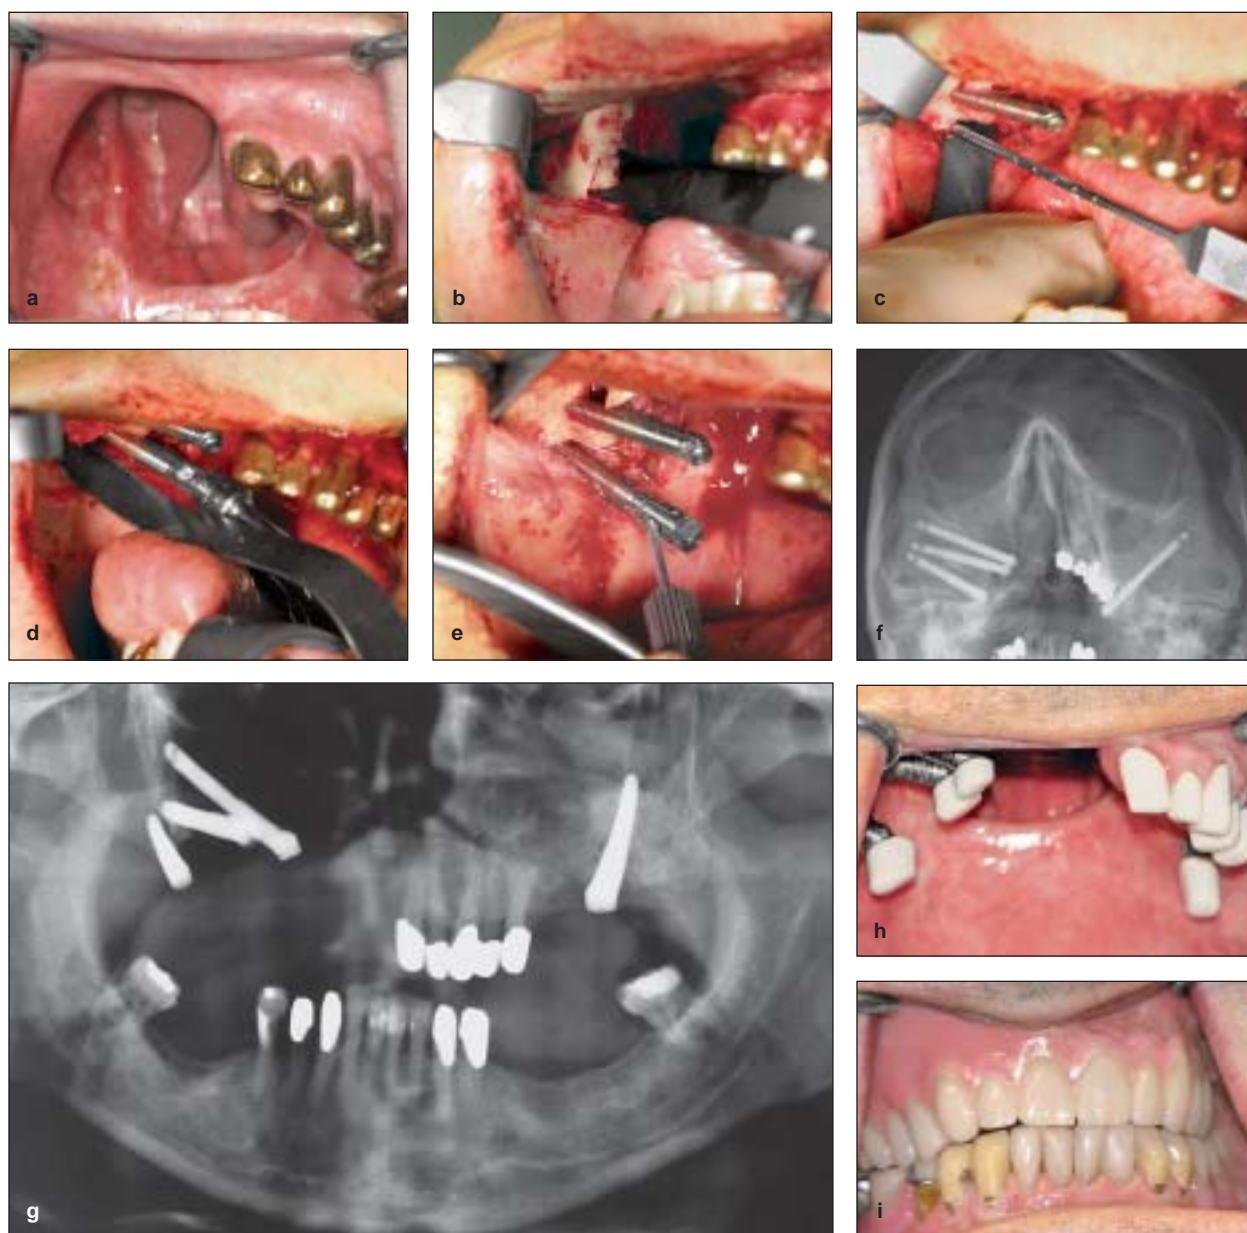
Patient 13: (a) the preoperative state; (b) during the intraoperative exposition of the zygoma after a former complete tumor resection; (c) with the most anterior first implant in place and the depth gauge within the second most posterior implant burhole; (d) placement of the second implant; (e) removal of the straight insertion post unveiling the 45 degree angulated platform; (f) and (g) postoperative radiographic controls; (h) the postoperative situation; and (i) the occlusal aspect with obturator prosthesis in place.
